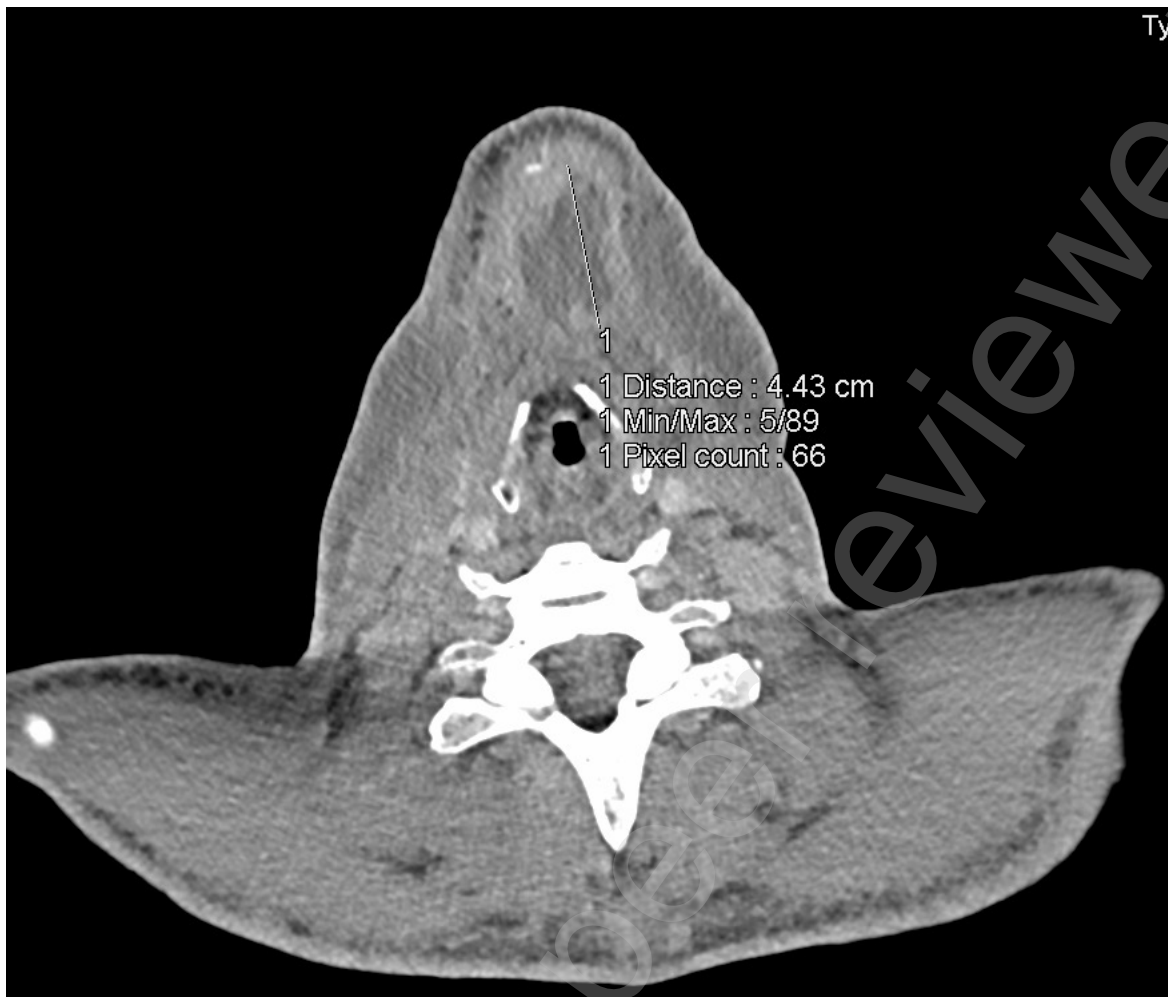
Axial View of Initial SR/CT of Head and Neck showing an ill-defined collection measuring 4.43cm across in the submental space under the mylohyoid muscle with fat stranding throughout the neck with extension around the left submandibular space
